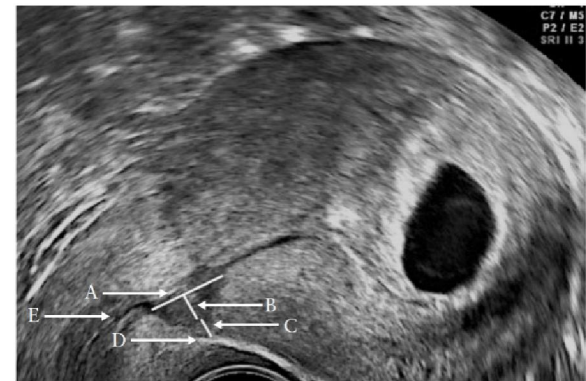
Sagittal ultrasound image showing anatomical location of features measured to quantify size of component parts of a Cesarean section scar using transvaginalsonography in first trimester of pregnancy. A, width of hypoechoic part; B, depth of hypoechoic part; C, residual myometrial thickness; D, uterovesical fold; E, internal cervical os (Naji et al., 2013).
